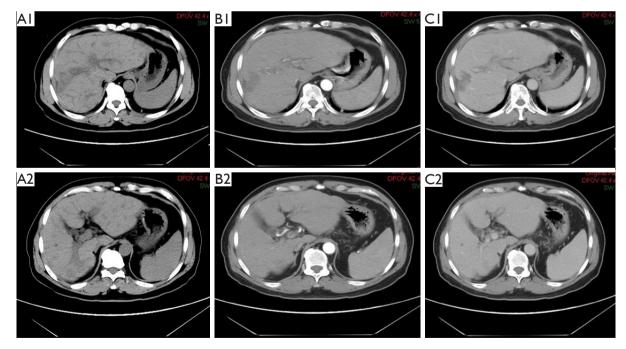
CT images of the tumor recurred after two cycles of HAIC. The primary lesion was smaller than that before the (A1,A2) unenhanced CT scanning phase, the (B1,B2) arterial phase and (C1,C2) portal venous phase. CT, computed tomography; HAIC, hepatic arterial infusion chemotherapy.
